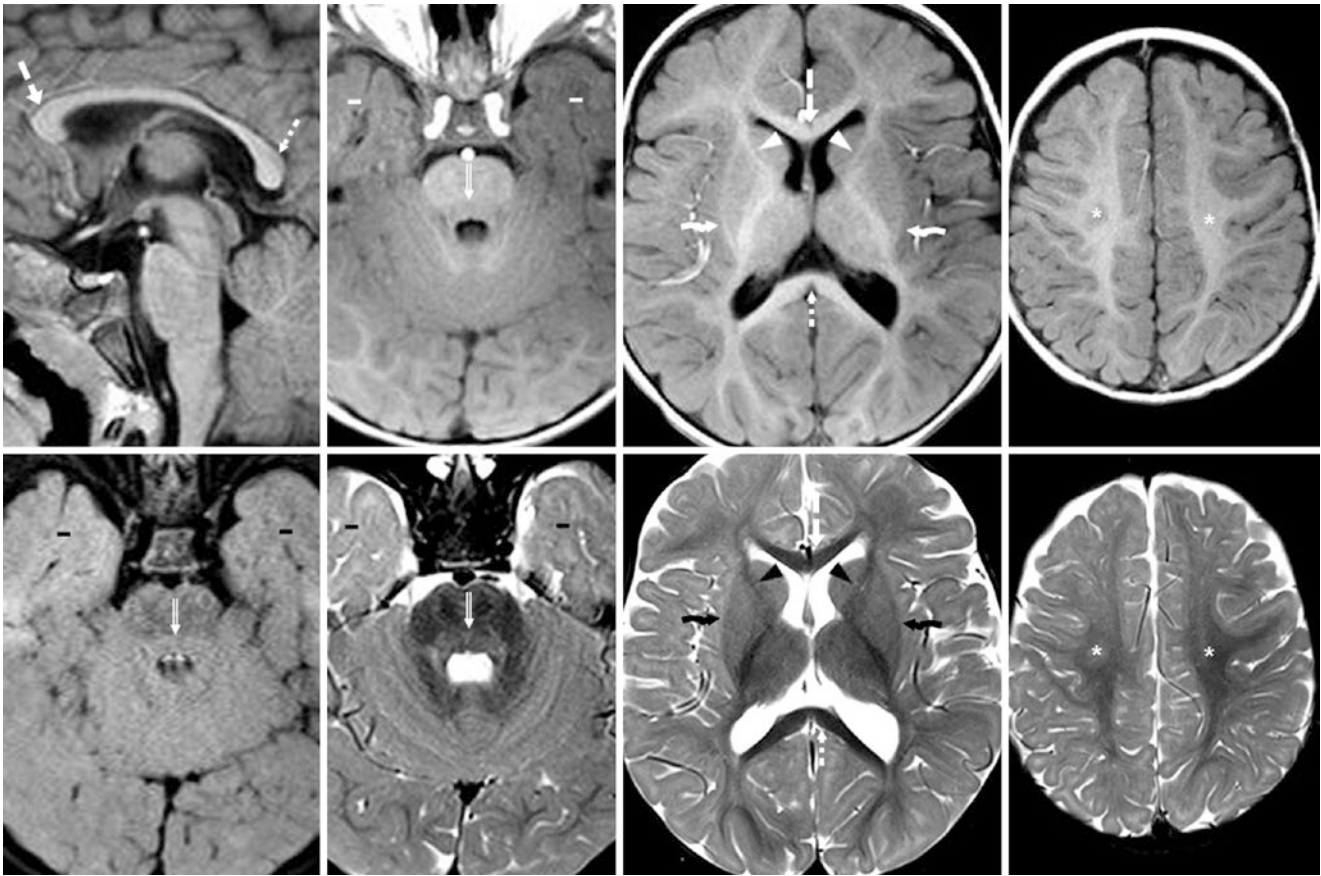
A 9.5-month-old with abnormal movements had a negative 3T MRI, and normal development. Sagittal GE T1WI (*top, left*) shows a mature CS (*dotted arrow*) and CG (*dashed arrow*). Axial T1WIs (*top, right three images*) show mature ALICs (*arrowheads*) and ECs (*crooked arrows*), which are mildly dark on SE T2WIs (*bottom, right three*
